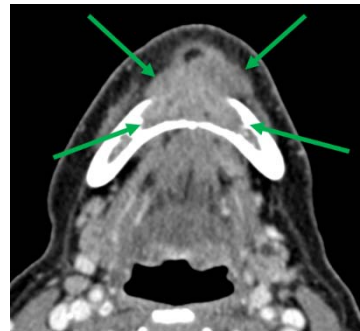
CT of the neck demonstrates a soft tissue mass (green arrows) along the anterior floor of the mouth that erodes into the mandible. Image courtesy of the University of Massachusetts Medical School, Department of Radiology.
